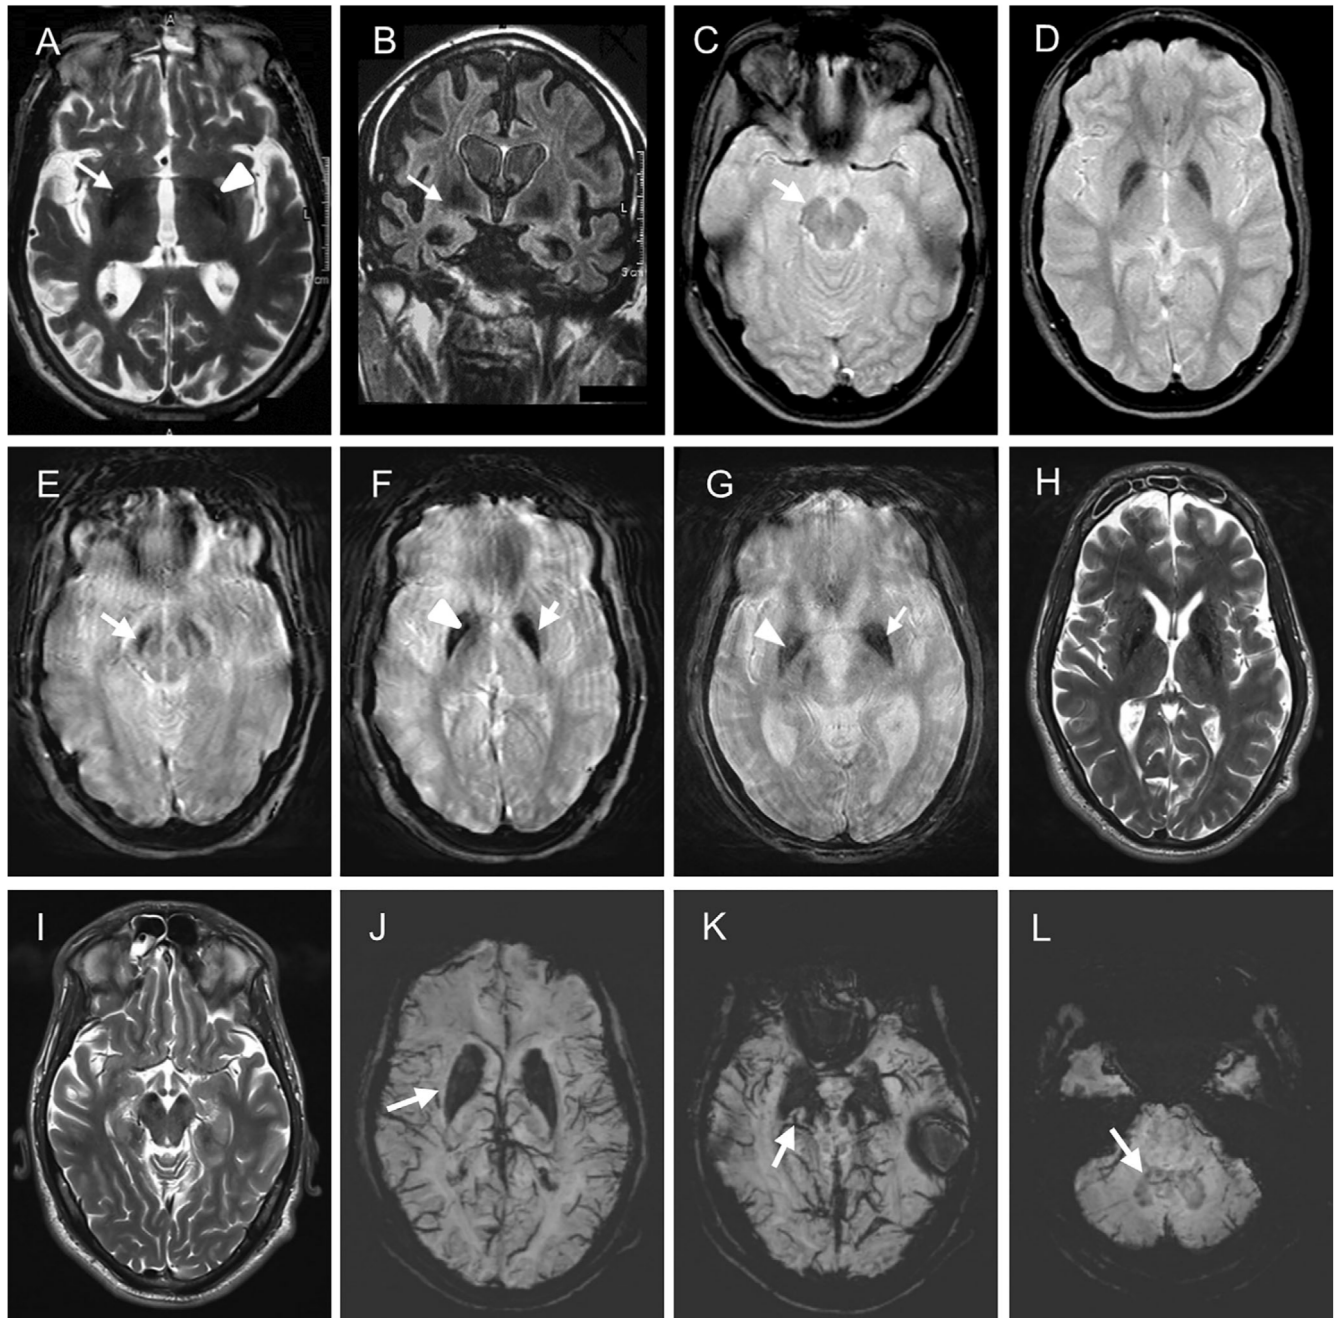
Brain magnetic resonance imaging. (A,B) Patient P2, axial T2-weighted imaging with hypointensity on globus pallidus (A) with discrete linear hyperintensity in left globus pallidus, suggesting intern medullary lamina sign (arrowhead). In (B) coronal fluid attenuated inversion recovery-weighted imaging with hypointensity on globus pallidus (white arrow) and cortical atrophy. (C-D) Patient P3 at 18 years (C,D) and 23 years (E,F). We observed a worsening of iron deposits on globus pallidus, red nuclei, and substantia nigra. Hypointensity in T2* or susceptibility weighted imaging (SWI) (white arrows) suggest iron deposits. In (F) linear hyperintensity in right globus pallidus (arrowhead) underlines the intern medullary lamina sign. (G) Patient P4, axial T2* weighted imaging with hypointensity on globus pallidus (white arrow), and suspicion of intern medullary lamina sign on right globus pallidus (arrowhead). (H,I) Patient P8, axial T2-weighted imaging with hypointensity on globus pallidus and putamen, red nuclei and substantia nigra; (J-L) Patient P8, axial mIP SWI (minimum Intensity Projection) with hypointensity on putamen, red nuclei, and dentatus nuclei.
